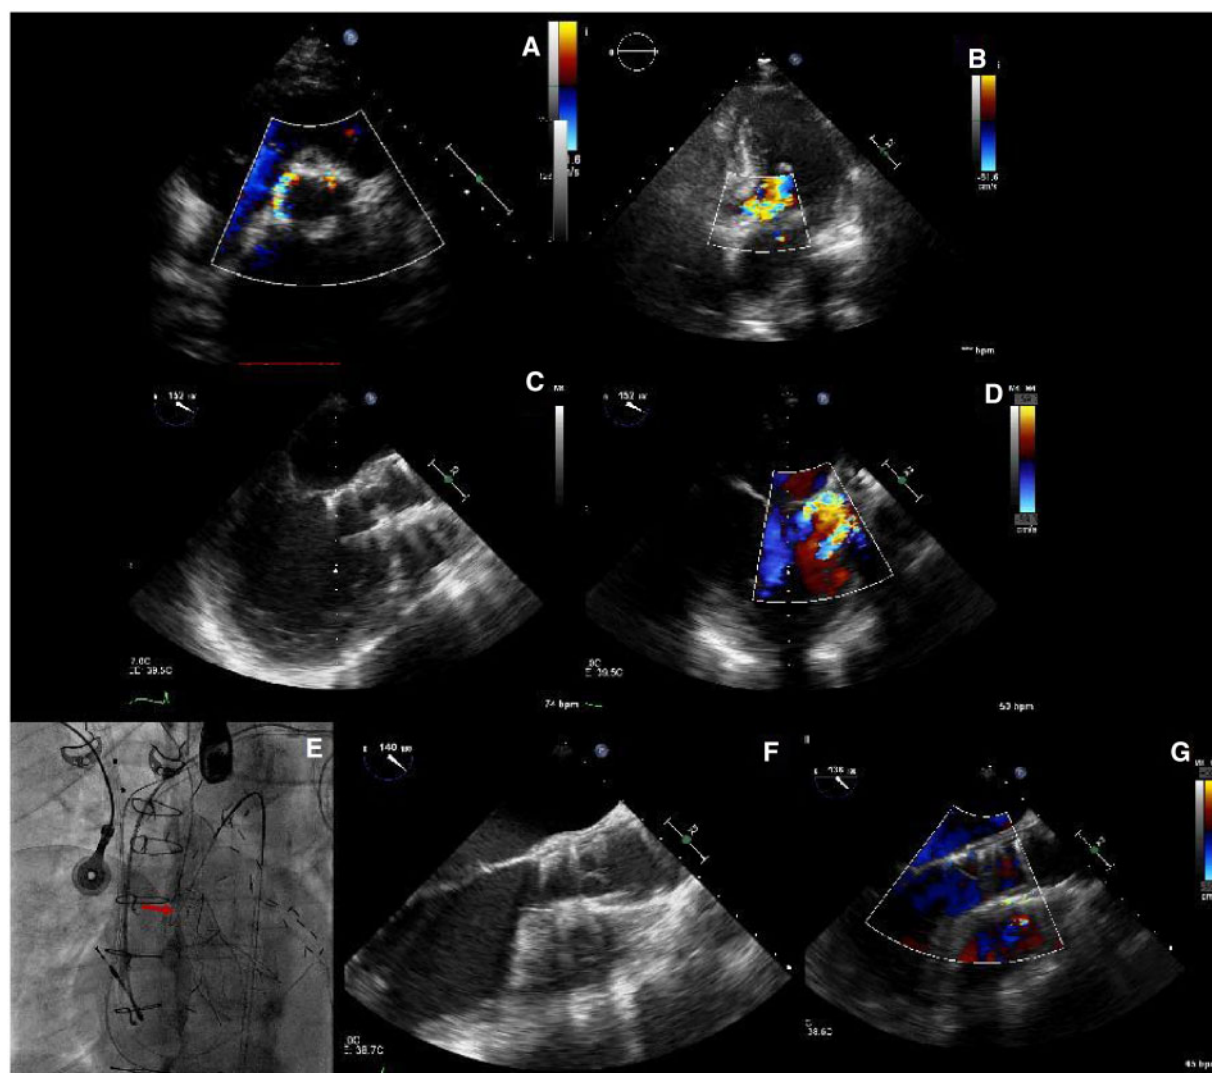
(A) TTE colour-Doppler parasternal short-axis view and apical five-chamber view (B) showing severe PVL. (C) TEE mid-oesophageal long-axis view confirming severe PVL (D), due to THV dislocation in LVOT. (E) Fluoroscopic view showing valve retrieval by the goose neck catheter. (F, G) TEE mid-oesophageal long-axis view shows the correct reposition of THV with the absence of PVL.
